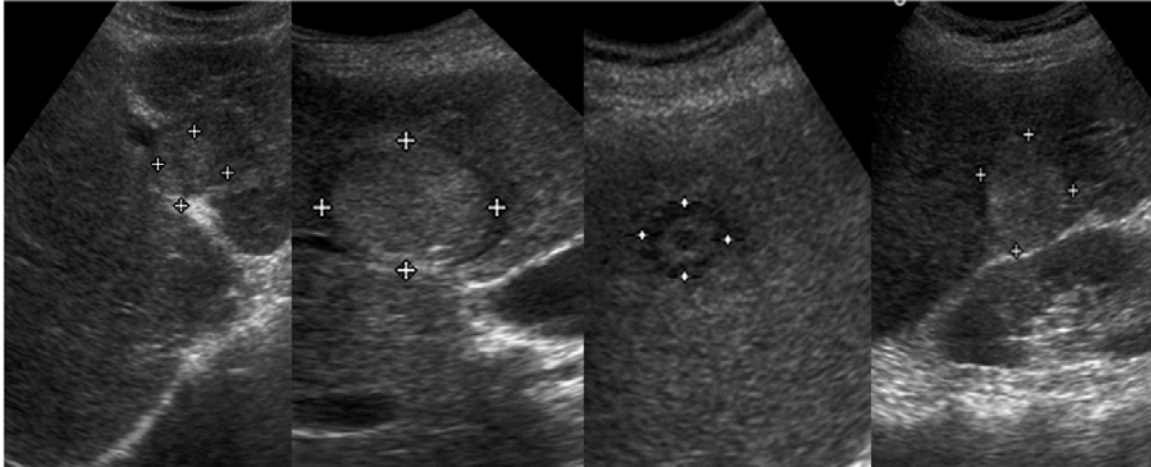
Ultrasound liver images with (a) SHCC image; (b) LHCC image; (c) typical MET image; (d) atypical MET image.
